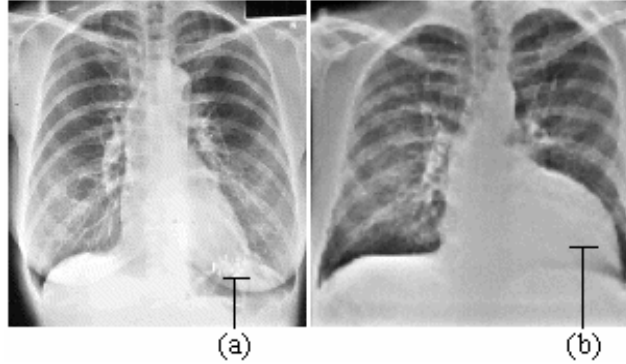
X-ray images of a heart [50].
